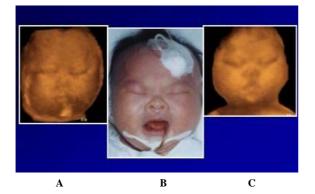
Three-dimensional surface rendered ultrasound image of a 34-week trisomy 21 fetus clearly visualize facial characteristics of Down syndrome manifesting in Mongolian slanted eyes and flat nasal bone (A and C). The same newborn baby, a few days after delivery (B).
